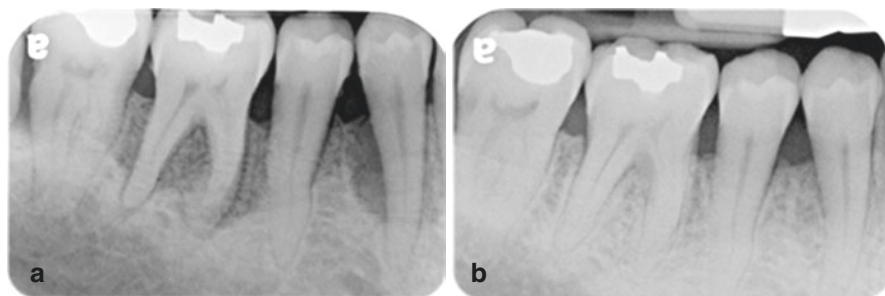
Laser therapy in the treatment of furcation lesions. (a) Preoperative radiograph showing mandibular first molar with class II furcation involvement. (b) 2-Year postoperative radiograph after treatment with LANAP[®] protocol (Nd:YAG laser) showing increased radiographic bone fill. Images courtesy of Dr. Steve Hamrick
